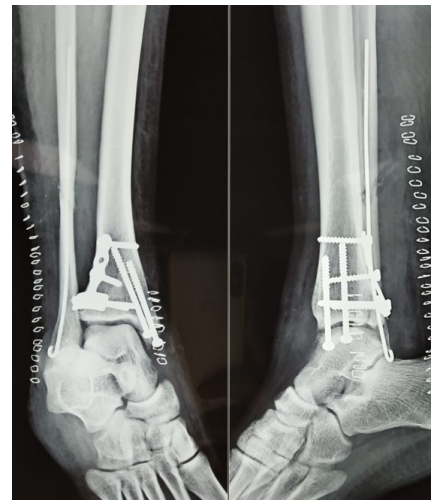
Immediate post op x-ray showing fixation of posterior malleolus by plate, fixation of medial malleolus by 2 screws and fixation of fibula by Rush nail.
